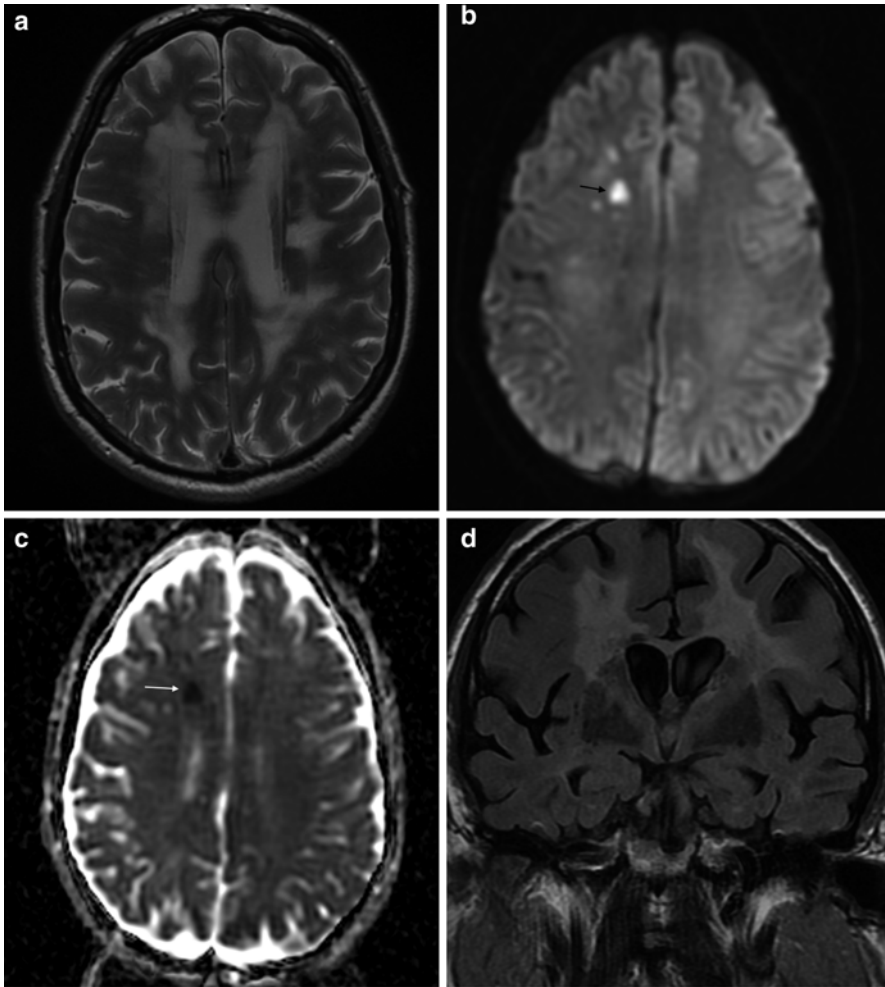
Detection of acute cerebral infarction with diffusion-weighted imaging. (a) T2 axial imaging showing extensive, confluent white matter abnormality with a discrete left corona radiata lacunar infarct. (b) Diffusion-weighted imaging (DWI) shows focal hyperintensity in the right frontal white matter. (c) Apparent diffusion coefficient (ADC) map demonstrates low ADC, i.e. restricted diffusion, in the right frontal white matter lesion, indicating acute infarction. (d) Coronal T2 FLAIR image fails to distinguish the acutely infarcted region from the background of small vessel ischaemic disease
